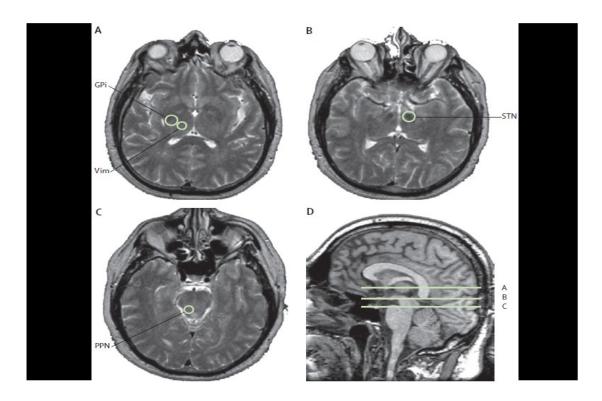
Main anatomical structures targeted by deep brain stimulation on T2-weighted brain MRI (reproduced with permission from Fasano et al. 2012).
